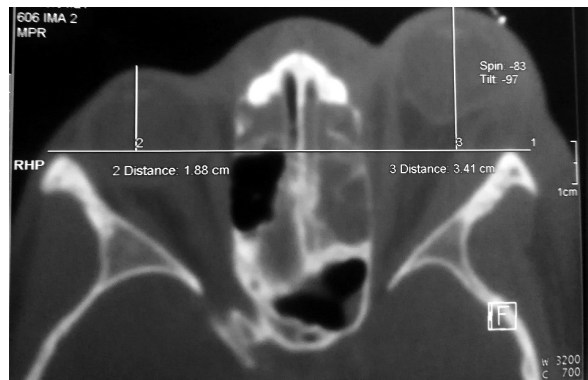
Orbital CT scan showing left orbital cellulitis with exophthalmos grade III complicating an acute ethmoiditis
